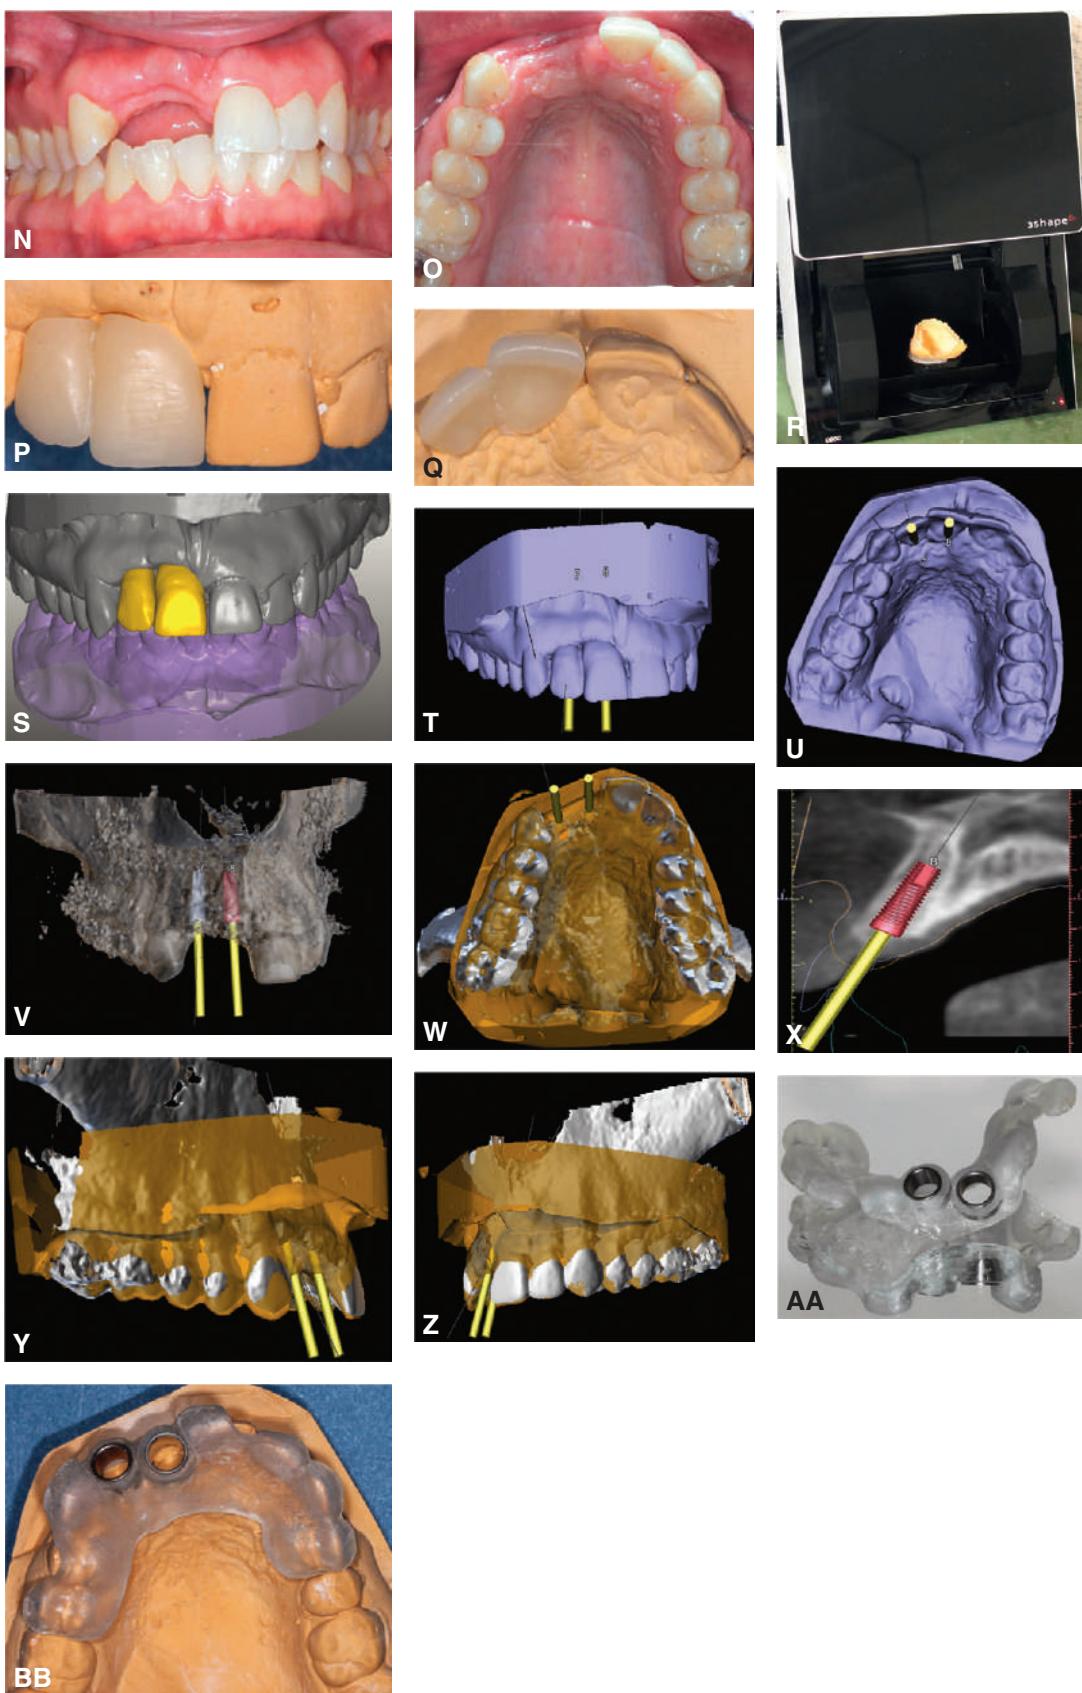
Cont'd (N and O) Missing right lateral and central incisors to be restored with two implants. (P and Q) Diagnostic waxing. (R) Laboratory scanner. (S) Laboratory scan of the diagnostically waxed cast. (T–Z) Incorporation of software-generated views of the waxed diagnostic cast into CT for virtual treatment planning. (AA and BB) CT-generated surgical guide.
